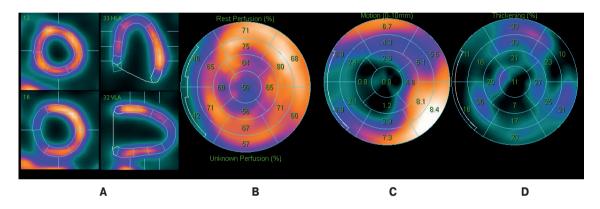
Myocardial perfusion SPECT of the patient with non-ischemic HF after CCM device implantation. A. Perfusion scintigrams. B. Polar map of LV perfusion. No worsening. C. Polar map of systolic LV wall motion. Reduction of LV cavity, restoration of systolic motion almost to normokinesis along all LV walls, except for the septal one. EDV of 125 ml, ESV of 79 ml, stroke volume of 46 ml, LVEF of 37% (N>50%) with heart rate of 86 bpm, cardiac output of 3,9 l/min. D. Polar map of LV systolic wall thickening. Reduction of LV systolic wall thickening persists.
